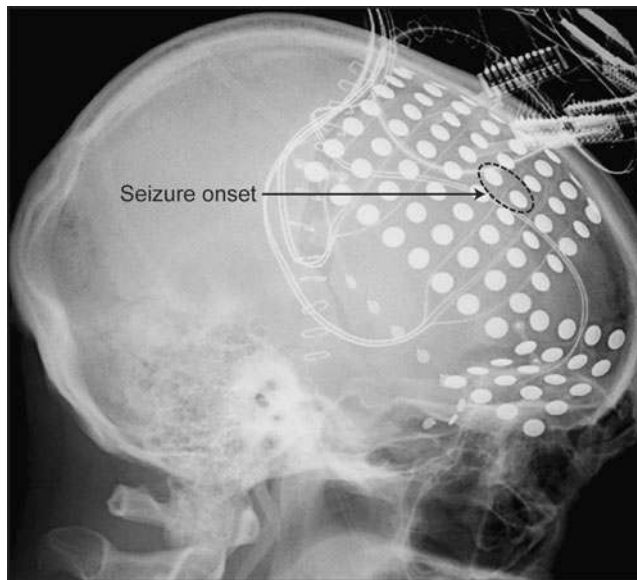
Skull X-Ray showing a combination of frontal grid electrodes and temporal strip electrodes used to localize the ictal zone.
